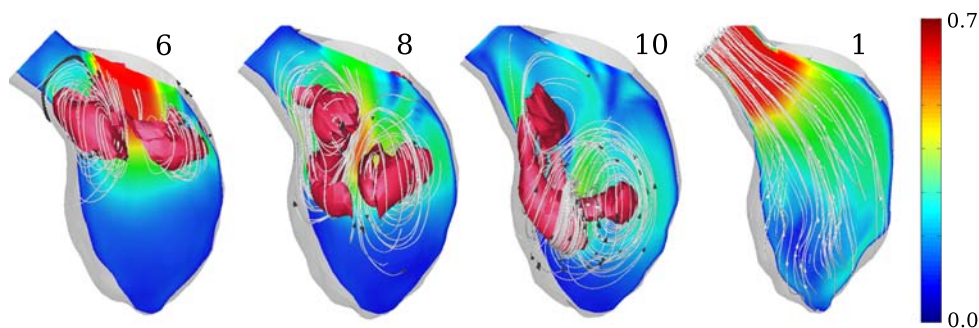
Flow structure in the left ventricle. Isosurface $\lambda_2 = -1000$ and 3D stream lines on velocity contour. Numbering corresponds to the MRI flux phases (see Fig. 5).
